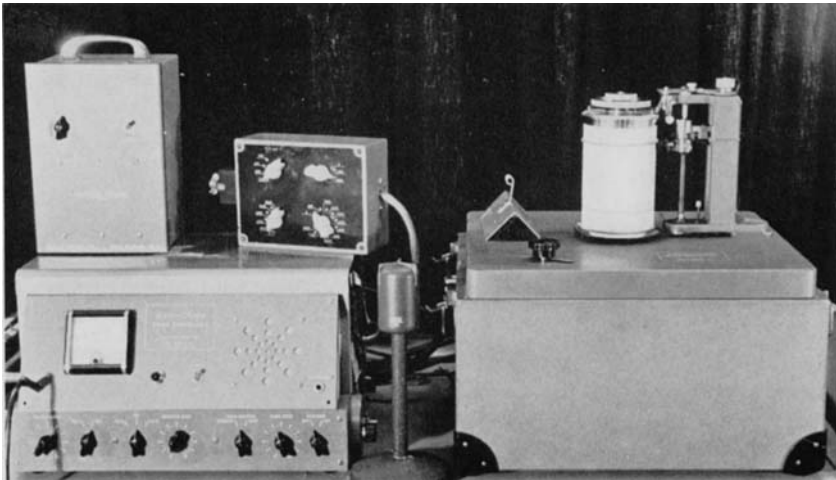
The sonographic apparatus.
